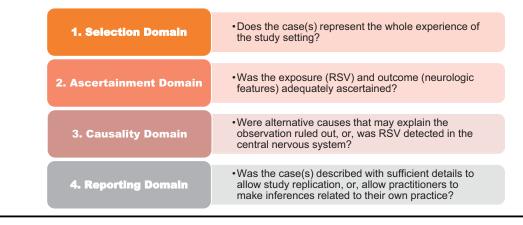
Quality assessment domains. The Causality Domain was informed by published guidelines for the investigation and causality of childhood encephalitis.^{10,84} To meet this domain, authors must have reported on prespecified investigations to exclude common alternate causes of acute neurologic symptoms. Sought investigations were analysis of CSF including cell count, cell type, and culture; CSF testing for enterovirus and herpes simplex virus; respiratory sample testing for enterovirus and influenza virus; and neuroimaging using either magnetic resonance imaging or computed tomography. Reports that demonstrated the detection of RSV in the CNS met the causality domain regardless of other reported investigations. Articles that met 3 or more domains were classified "higher quality" and all others were classified "lower quality."
